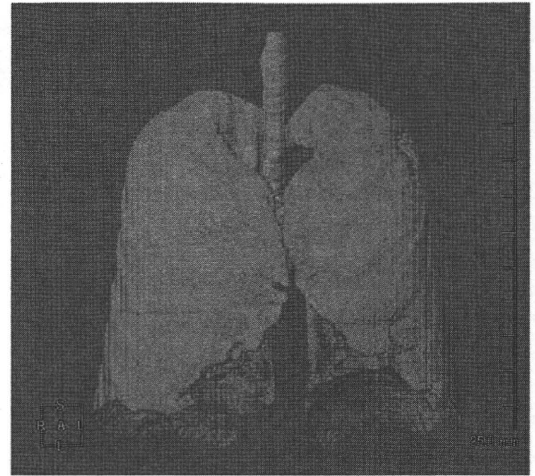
Lung mask image. Three-dimensional (3D) computed tomography (CT) images of the lung were obtained by threshold processing
